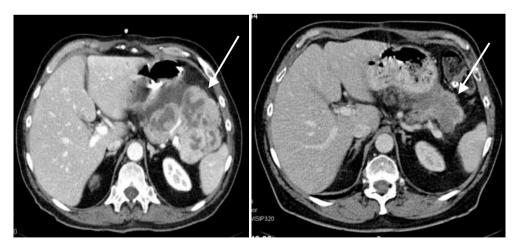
CT scan images in a patient with a non-functioning neuroendocrine tumor of the tail of the pancreas (arrows) before (left) and 6 weeks after the last treatment with ¹⁷⁷Lu-DOTA-tate. Before the treatment, the patient had lost more than 15 kg of body weight. At the time of scanning 8 months later (right), he had regained 14 kg. Scaling is identical. Notice the decrease in tumor size and the increase in body circumference.
